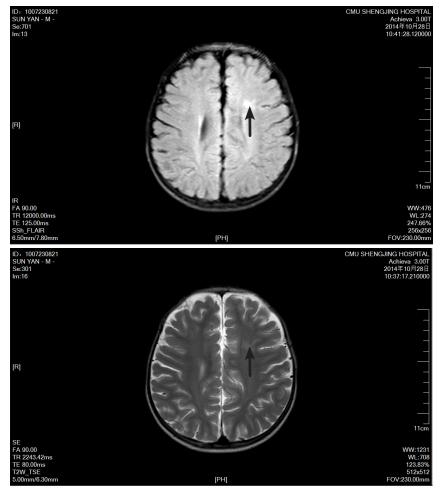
Brain magnetic resonance imaging of the boy at 4 and half years old
